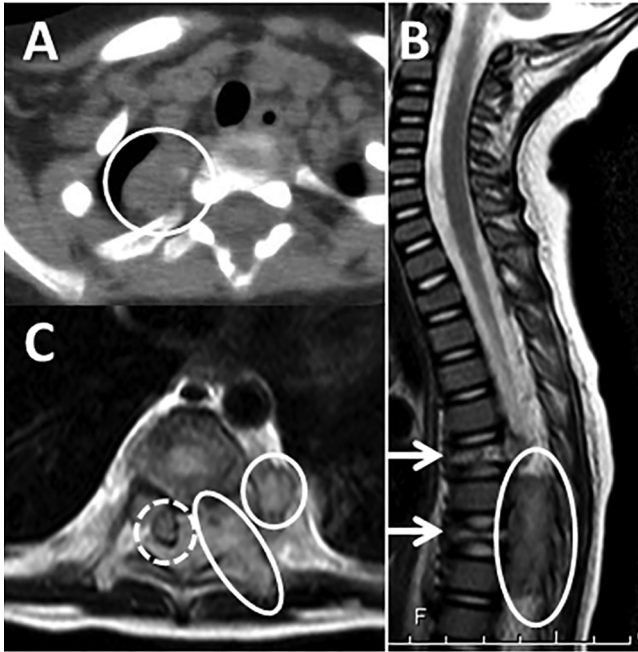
Computed tomography and magnetic resonance imaging of the whole spine. (A) Mass lesion in the right upper lung. (B) T2-weighted images show compression deformity of the T6 and T8. (C) A mass lesion in the epidural region at the Th7-9 levels compresses the spinal cord (arrows). Ovals and dashed circles indicate the appearance of LCH tumor (A-C) and the rightward-deviated spinal cord (C), respectively.
